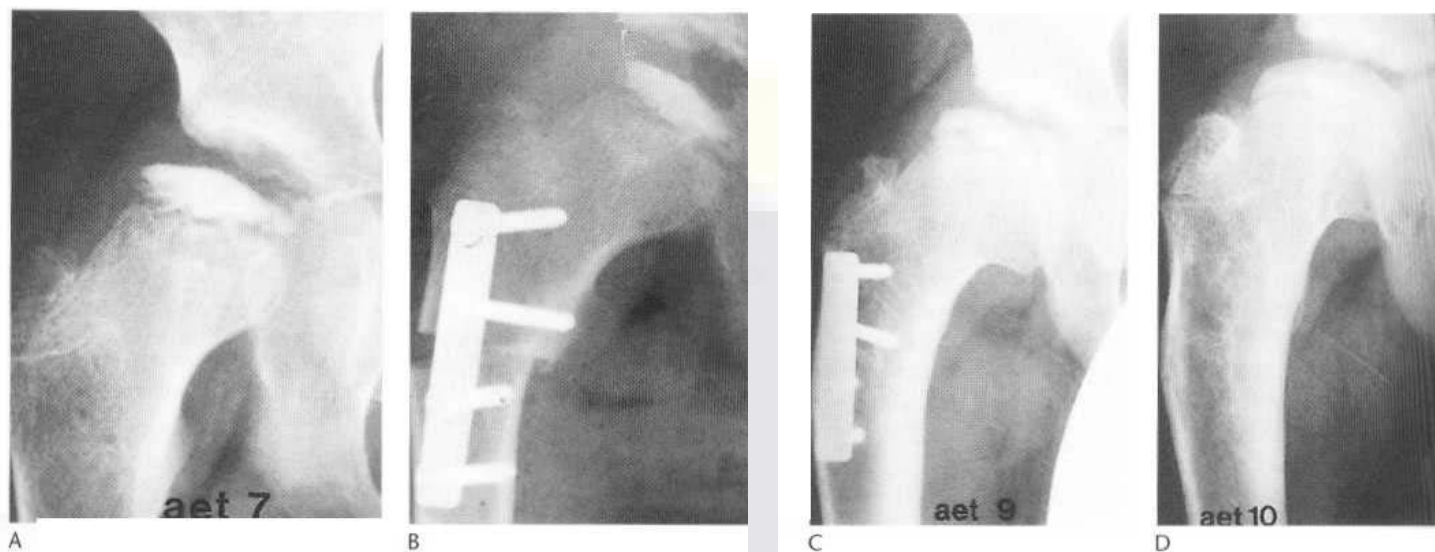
Perthes' disease. A series of radiographs showing the stages of healing. (A) The initial radiograph shows a flattened, sclerotic femoral head. (B) An osteotomy is performed. (C, D) Later films show resorption of the sclerotic dead bone and its replacement with vital bone, resulting in a mushroom-shaped femoral head.
